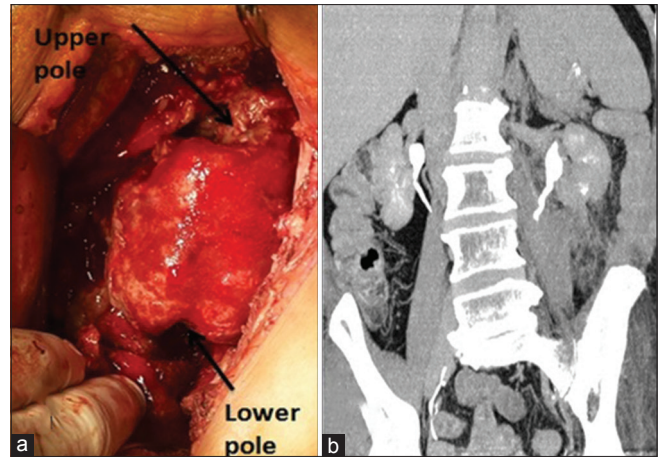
(a) Perinephric pus pockets with completely destroyed upper and lower pole of the kidney with spared middle lobe. (b) Contrast-enhanced computed tomography-kidneys, ureters, and bladder at 2 months showing the spared kidney with good parenchyma and normal function
